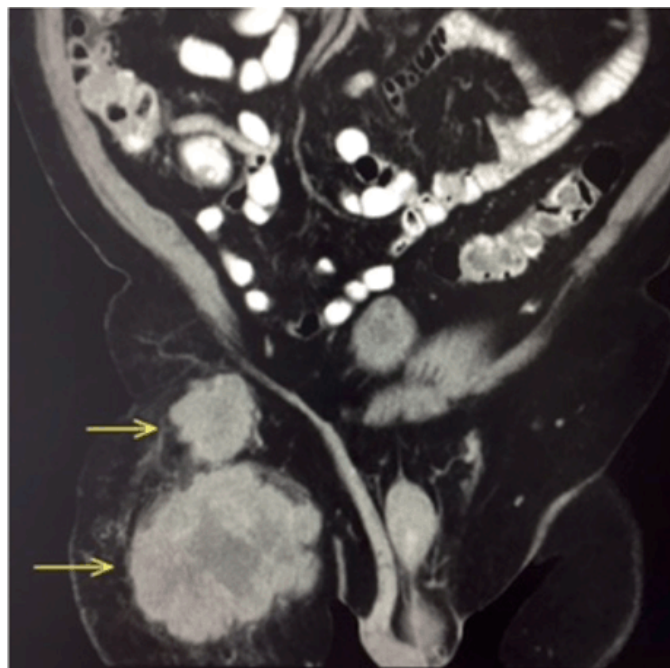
Coronal abdominal computed tomography scan of the abdomen at presentation showing two inhomogeneous masses in the right groin (yellow arrows).
